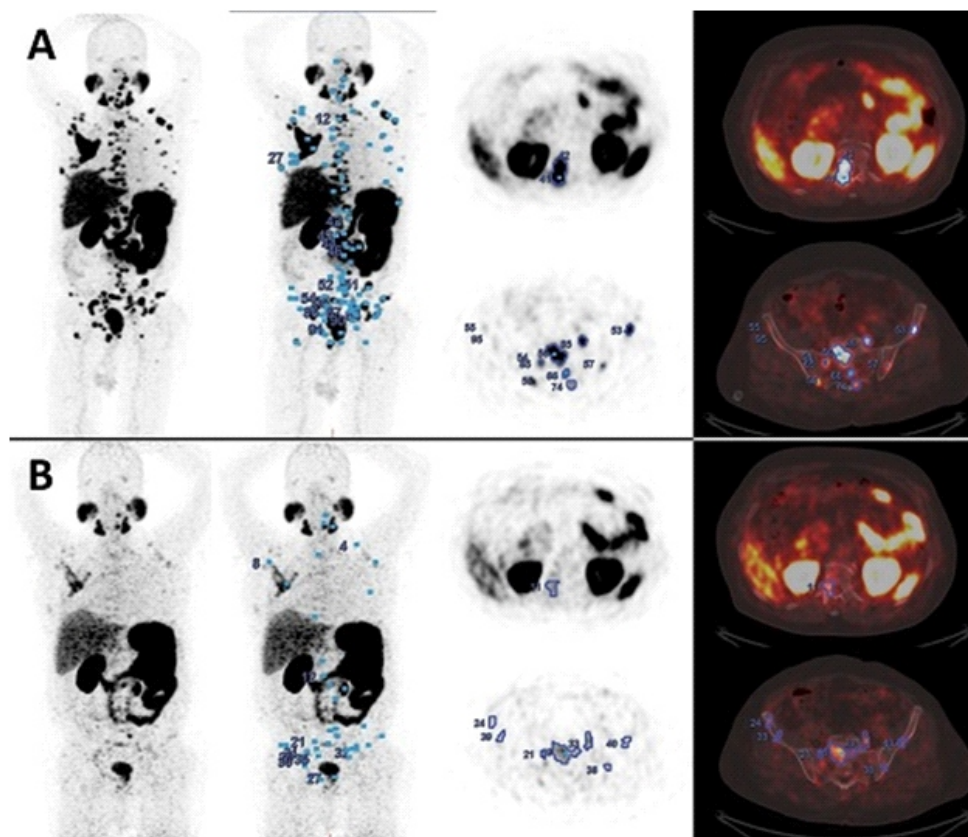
A 73-years old male patient was diagnosed with prostate cancer. His Gleason score was 4+5=9, and initial PSA level was 145ng/mL. Initial ⁶⁸Ga-PSMA PET/CT showed (A: MIP, PET, and fusion images) MTVw1:208, TLPw1:4842, Hpeak1:43.19, and HBNpeak1:19.63. After docetaxel therapy, his PSA level regressed to 14.8ng/mL. Post-treatment ⁶⁸Ga-PSMA PET/CT (B: MIP, PET, and fusion images) revealed MTVw2:95, TLPw2:1139, Hpeak2:26.7, HBNpeak2:16.3, indicating both partial biochemical response (Δ PSA: -89.7%) and partial PET/CT response (Δ MTV: -54.4%, Δ TLP: -76.5%).
